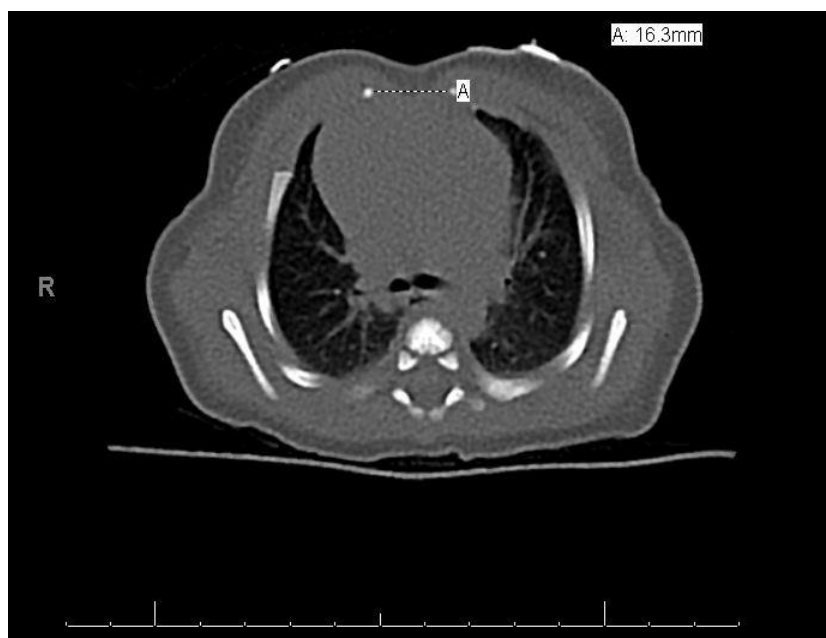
CT of chest showing 16.3mm sternal cleft.
